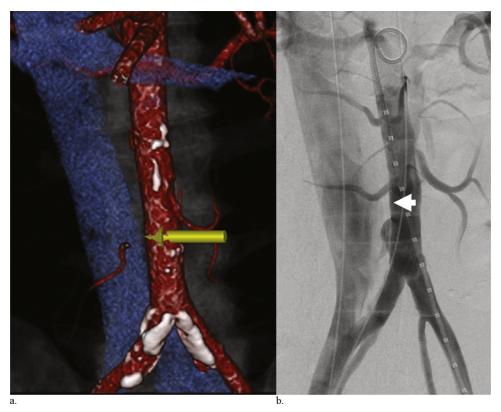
(a) Volume-rendered three-dimensional reconstruction of preoperative CT angiogram demonstrates the ideal target area for puncture from the IVC into the abdominal aorta (green arrow). (b) Simultaneous aortogram and cavogram demonstrate the intended puncture site (arrow).
